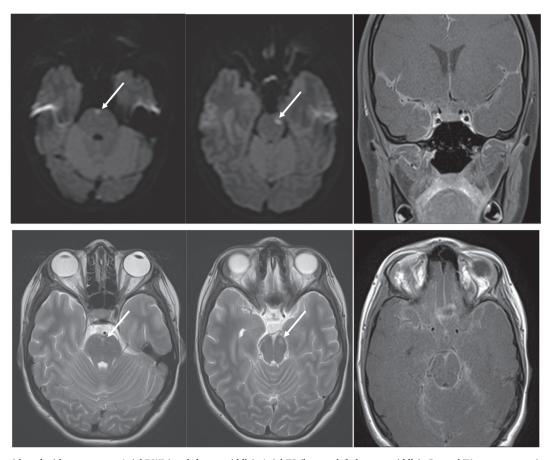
MRI brain with and without contrast. Axial DWI (top left, top middle), Axial T2 (bottom left, bottom middle), Coronal T1 post-contrast (top right) and Axial T1 post-contrast (bottom left). Focal lesions with restricted diffusion within the midbrain and pons (arrow). Diffuse abnormal leptomeningeal enhancement within the basal cisterns and sylvian fissures. Images obtained 37 days prior to patient's fatal outcome (image obtained 8 days after Fig. 1).
